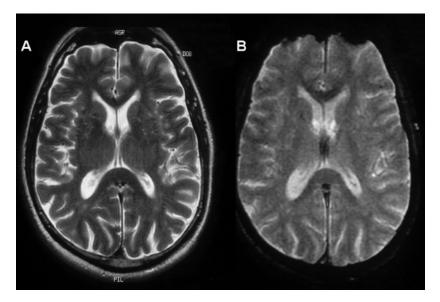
(A) Axial T2-weighted FSE and (B) T2*-weighted gradient-echo MRI of a 73-year-old male patient with normal executive function. Note the absence of well-defined low signal foci on gradient-echo MRI.
